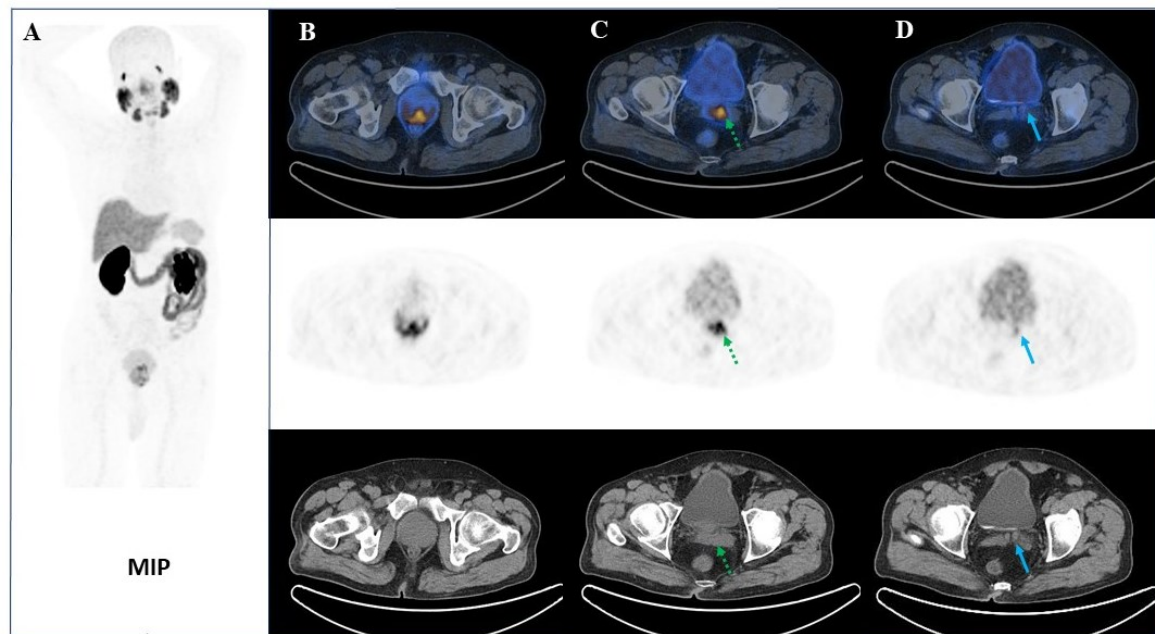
[^{68}Ga]Ga-PSMA PET/CT images showing uptake in the primary prostate tumor (B), left seminal vesicle base (C, dotted arrows), and ampulla of the vas deferens (D, arrows)
